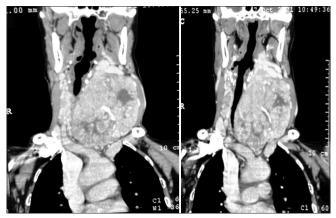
CT film of the neck and upper chest showing diffuse swelling of the thyroid gland and substernal goiter, which extends to left side of thorax. The goiter extended upto the right brachiocephalic vein with both trachea and esophagus shifted
